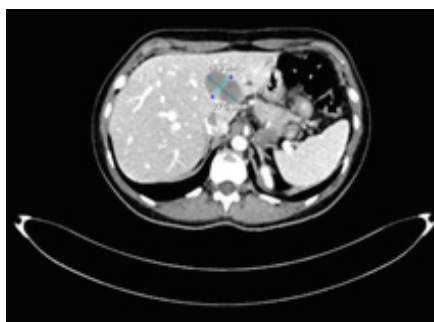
CT scan of the abdominal cavity with intravenous contrast, axial section. Two merging hypodense lesions in the II+III segments of the left lobe of the liver, with total dimensions of 41×27 mm
